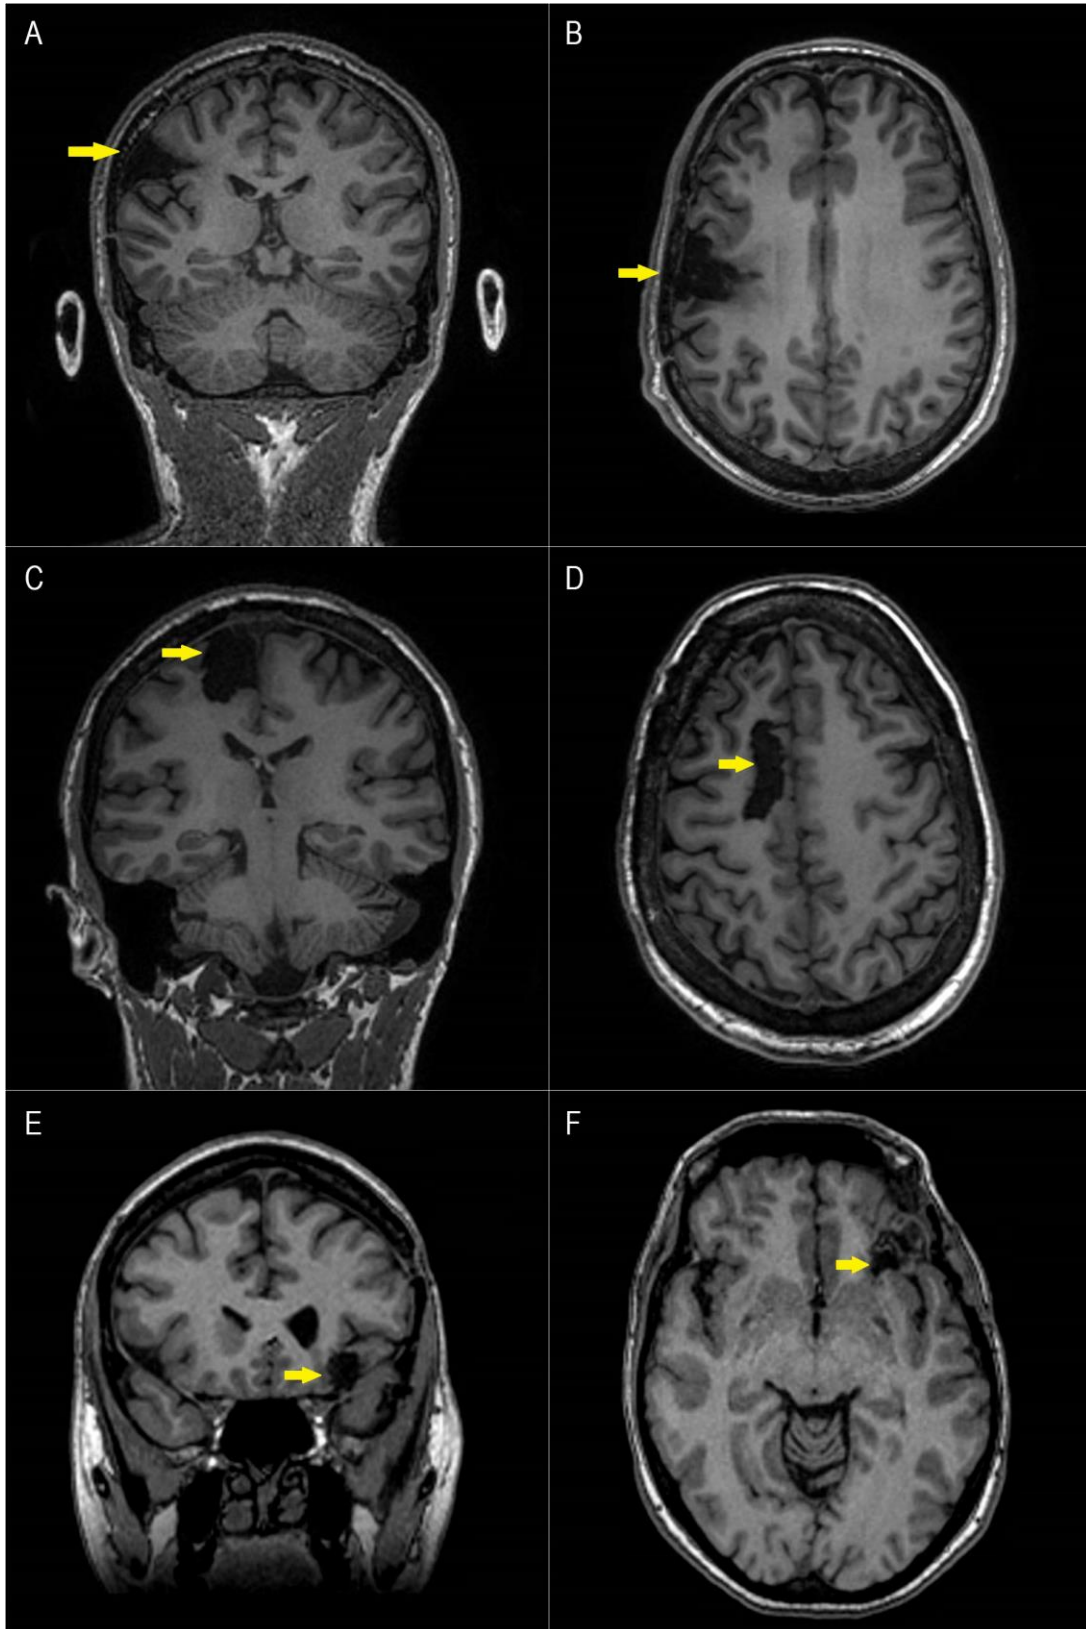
Dorsolateral resection for right focal cortical dysplasia in coronal (A) and axial (B) views. Frontomedial resection of right supplementary motor area in non-lesional epilepsy in coronal (C) and axial (D) views. Orbitopolar resection of left cavernoma in coronal (E) and axial (F) views. All images are T1-weighted 3T MRI sequences; yellow arrows indicate site of resection.
